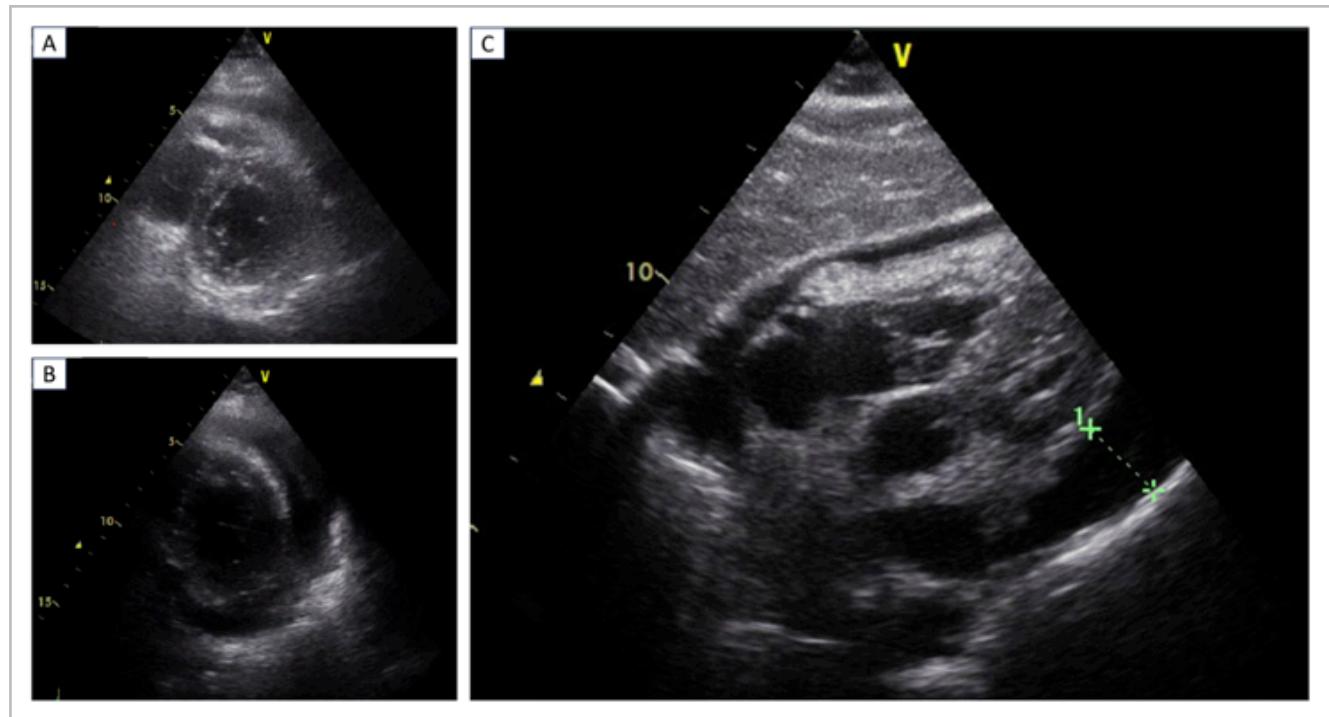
Transthoracic echocardiogram. Case 1: A and B: thickened, reactive pericardium with large fibrin deposits. C: severe pericardial effusion measuring 2.8 cm.
